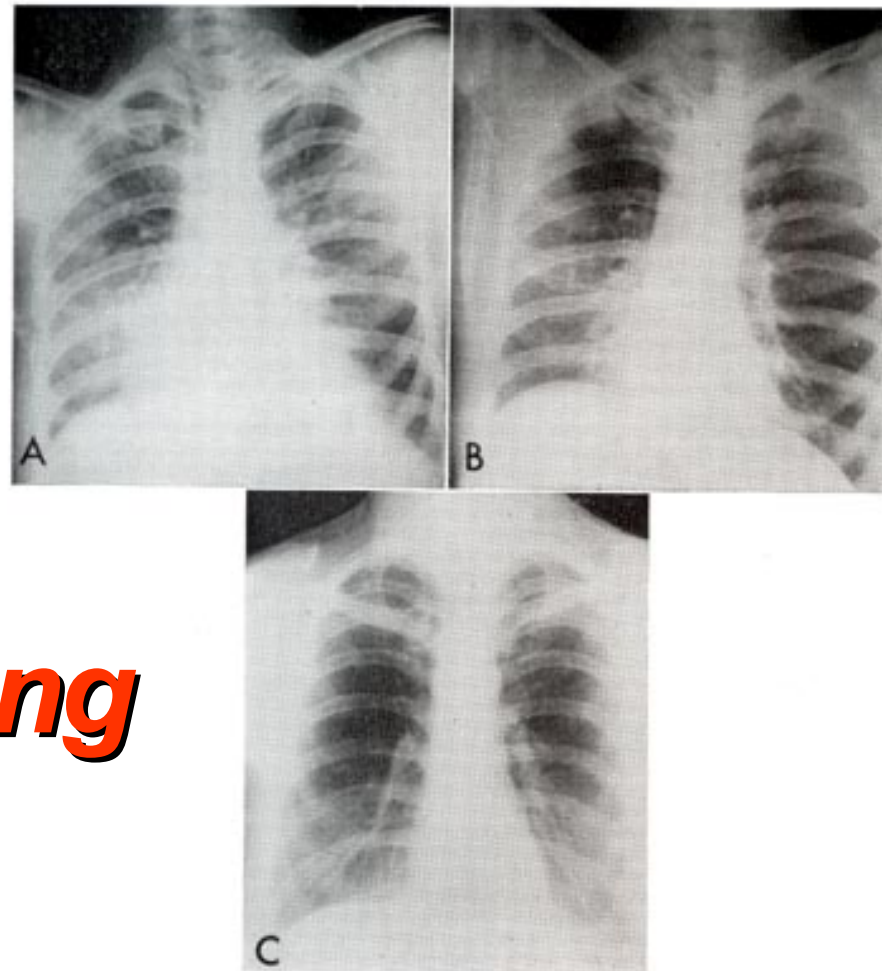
(case 5).—Serial roentgenograms in blast injury. A. Posteroanterior roentgenogram, 11 November 1943, 24 hours after injury, showing diffuse bilateral haziness and infiltration indicative of petechial pulmonary hemorrhage and edema. B. Posteroanterior roentgenogram, 17 November 1943, showing clearing of lung field. C. Posteroanterior roentgenogram, 7 January 1960, 16 years after severe blast injury. The only abnormality is slight emphysema of upper lobes. The diaphragms are at level of the eleventh ribs; their contours are rounded. Heart is also normal.
